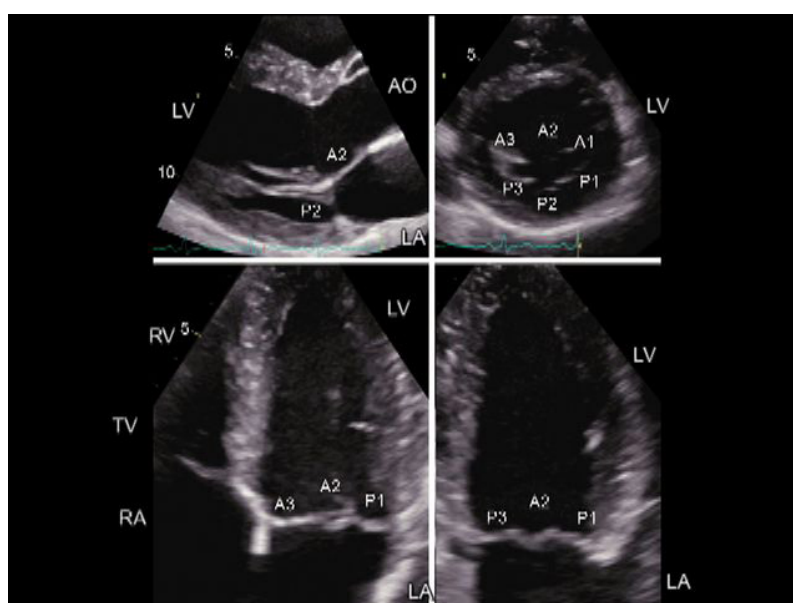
Mitral valve segment and scallop analysis with two-dimensional transthoracic echocardiography. Left upper panel: parasternal long-axis view depicting A2 segment and P2 scallop. Right upper panel: parasternal short-axis view permitting the assessment of A1, A2 and A3 segments and P1, P2 and P3 scallops. Left lower panel: apical four-chamber view showing A3, A2, and P1. Right lower panel: apical two-chamber view displaying P3, A2 and P1. RA: right atrium; RV: right ventricle; LV: left ventricle; LA: left atrium; TV: tricuspid valve; AO: aorta. Reproduced with permission from Pierard *et al.*^[11]
